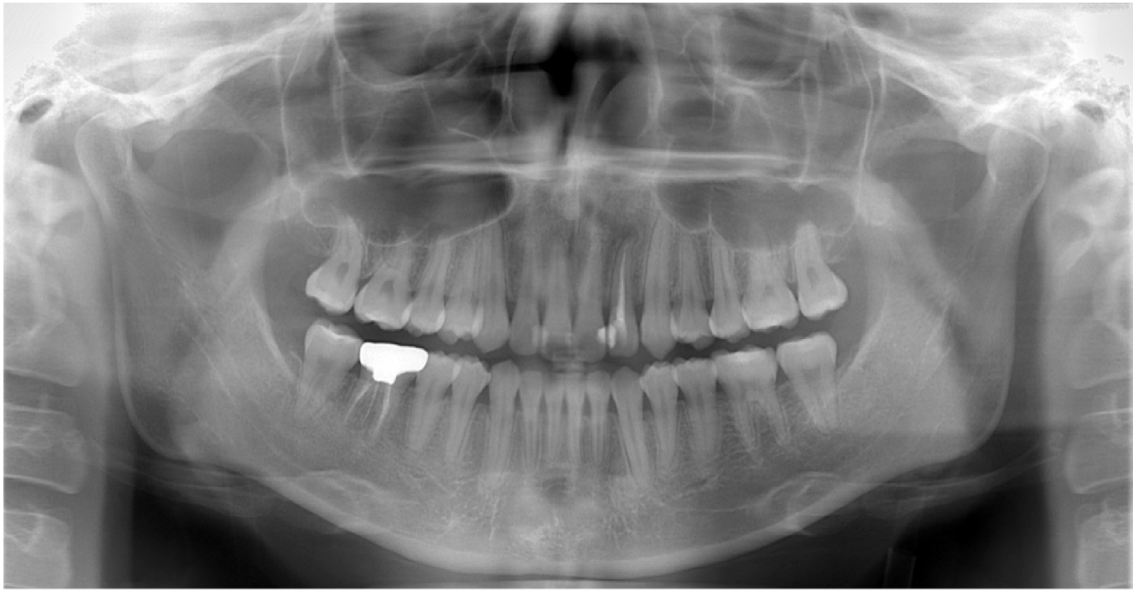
Post-treatment radiographic films.
